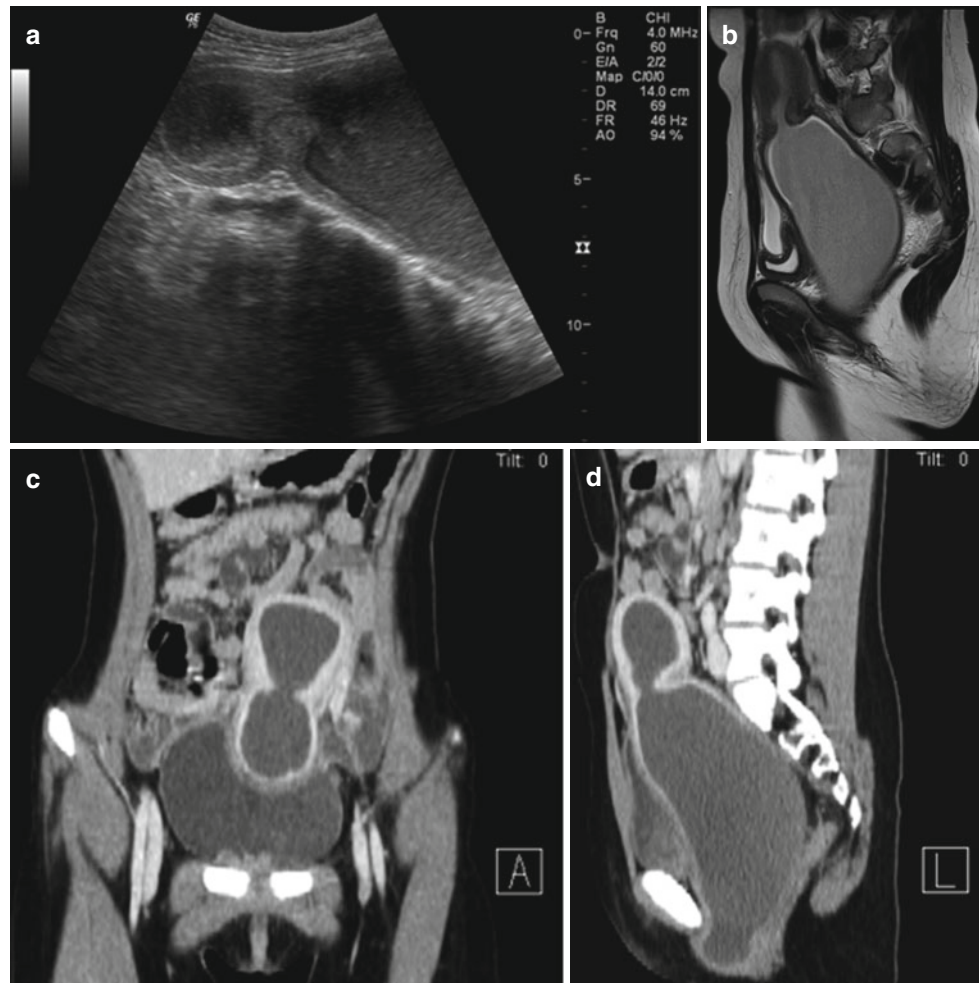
Hydrometrocolpos in a 12-year-old girl with amenorrhea. (a) Longitudinal US shows a dilated, echogenic fluid-filled vagina and uterus. (b) T2-weighted sagittal MR image shows markedly dilated
